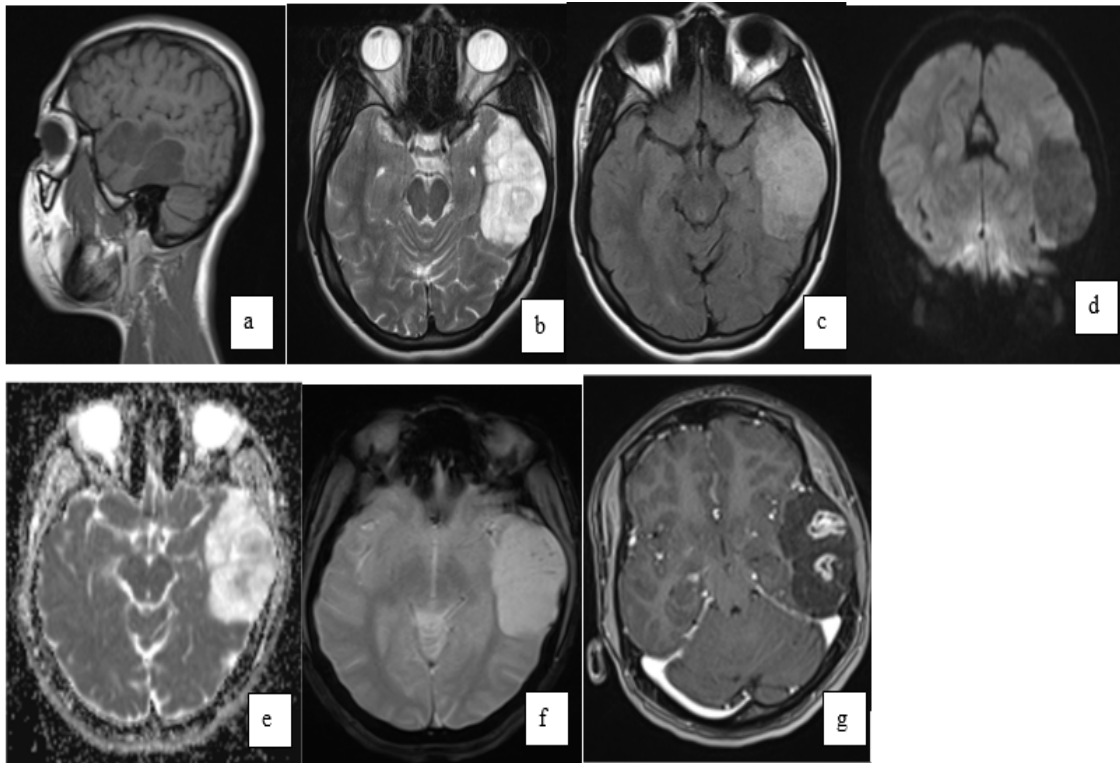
Brain MRI in axial and sagittal section showing a hypo signal left temporal cortico-subcortical lesion with a fleshy area in T1-weighted hyposignal (a). The latter has a microcystic with the fleshy area in T2-weighted hypersignal (b) and Flair, with no mass effect or peri-lesional oedema (c), with hypersignal on the diffusion sequence(d) with low ADC (e) , Absence of a signal-free area on the gradient echo sequence indicates calcification or hemorrhage (f). On the 3D T1 sequence after injection of gadolinium, there is annular contrast of the two fleshy lesions (g)
